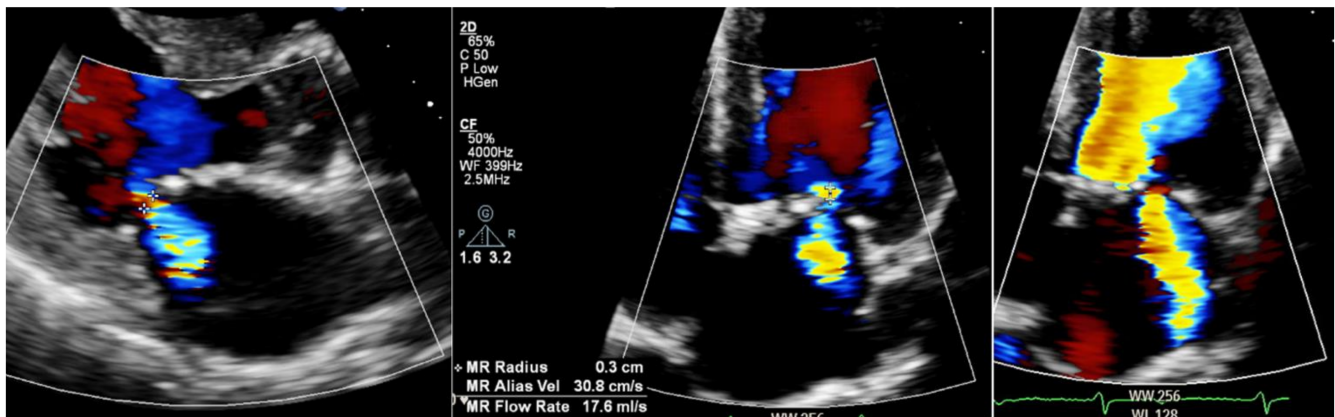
The 2D TTE MR assessment in an adult with advanced Fabry cardiomyopathy and co-existing end stage renal disease. (Left) Parasternal long axis view demonstrating LVH, left atrial dilatation, bilateral annular calcification of the mitral valve (causing basal restriction) with moderate MR evident on colour Doppler and vena contracta of 0.4 cm (moderate); (Middle) Apical 4-chamber view demonstrating bilateral annular calcification of the mitral valve with MR on colour Doppler and proximal isovelocity surface area (PISA) measurement of 0.3 cm (moderate); (Right) Apical 4-chamber view demonstrating moderate MR on colour Doppler.
